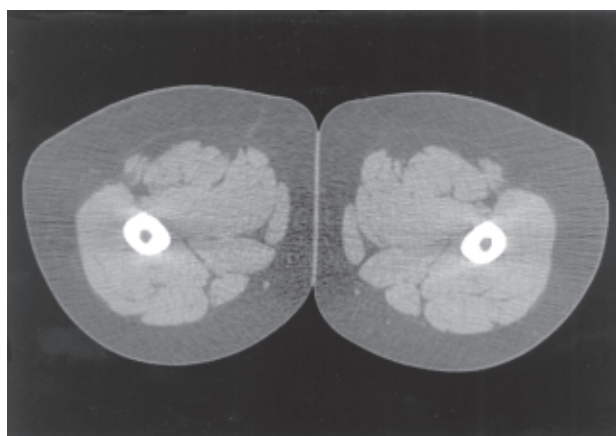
Computed tomography scan through the upper thighs demonstrates excessive fat deposition, which is out of proportion to the fat deposition throughout the rest of the body.
